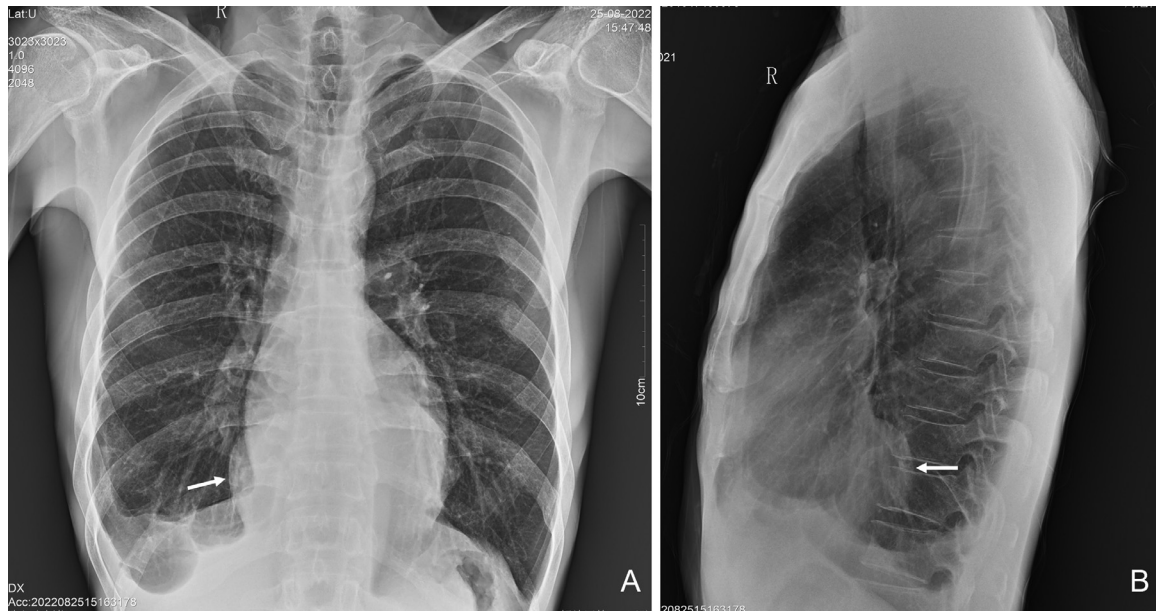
Orthostatic chest x-ray (A) shows circular high-density shadows overlapping in the cardiac shadow area (white arrow), and the lesion is located in the posterior mediastinum on lateral view (white arrow in B).
